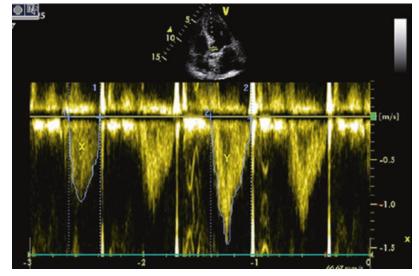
Apical five-chamber view, TTE. Wide VTI fluctuation during a mechanical breath in a clearly fluid-responsive patient.  $X = \text{VTI } 19.1 \text{ cm}; Y = \text{VTI } 29 \text{ cm}. \Delta \text{VTI} = 100 \times (\text{VTI}_{\text{max}} - \text{VTI}_{\text{min}})/(\text{VTI}_{\text{max}} + \text{VTI}_{\text{min}}/2) = 43\%.$  See the text for further details
